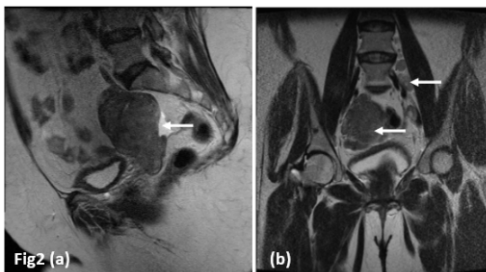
MRI sagittal (a) T2 W image of carcinoma cervix (Stage III A). Shows a large cervico infiltrative growth seen invading the cervical stroma and extending into both parametria. (b) MRI coronal T2 W image. Few enlarged T2 hyperintense /T1 isointense to hypointense enlarged pelvic lymph nodes seen at bilateral external, internal iliac, left common iliac and left inguinal lymph nodes.
